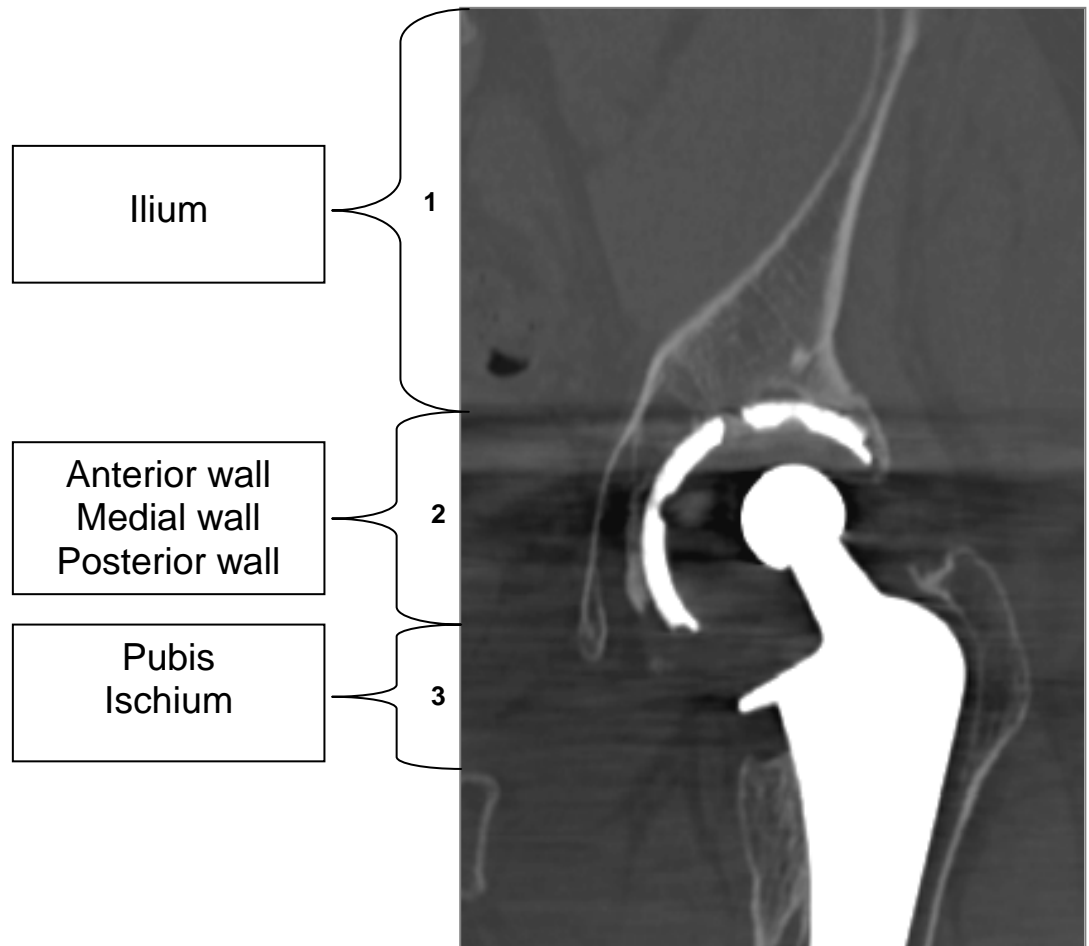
CT coronal reconstruction image of left hip joint in a patient with an uncemented total hip replacement prosthesis. Shown are 3 zones with different amount of metal artefact: Zone 1-involves the area cranial to the acetabular roof (ilium); Zone 2-involves the area on the level of the acetabular component (anterior wall, medial wall and posterior wall); Zone 3- involves the area caudal to the acetabular component (pubis and ischium).
